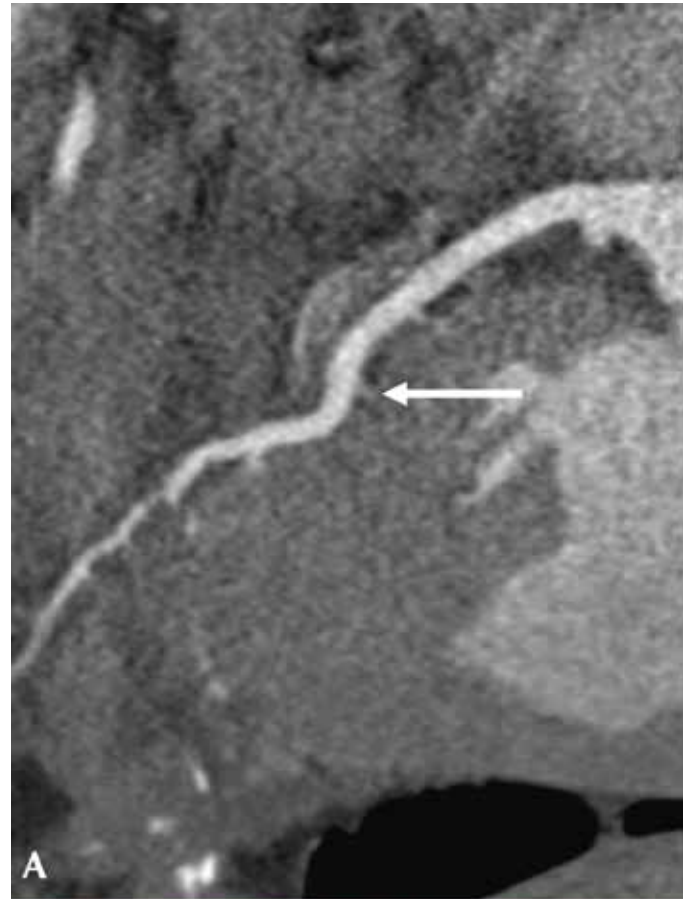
(A) Postoperative computed tomographic angiogram of the retrobypass of the (*) left internal thoracic artery. (B) 3D reconstruction of the filling of the vena interventricularis anterior through the retrobypass.
